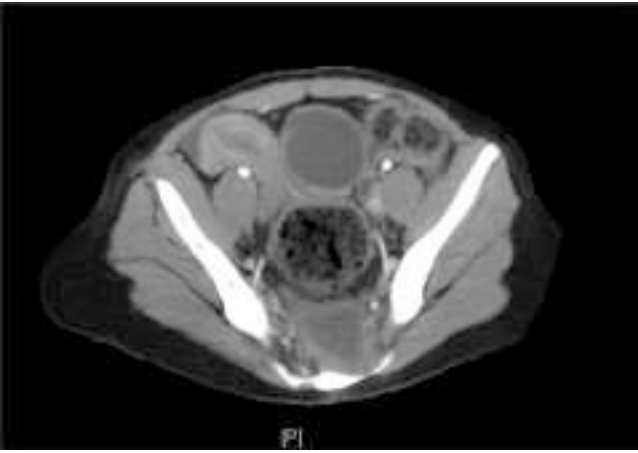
CT image of rectal duplication cyst.
